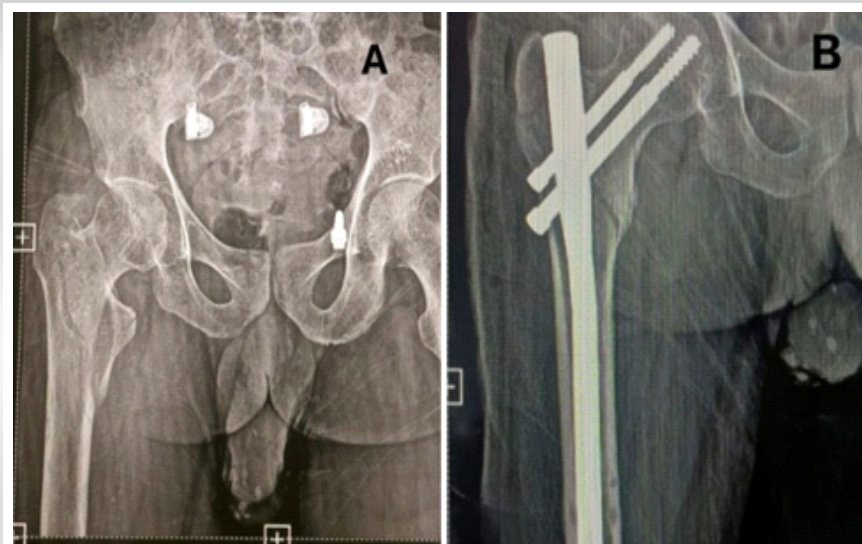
(a) Pre-operative anterior-posterior (A-P) view X-ray showing TYPE 31-A2.1 pertrochanteric femur fracture of the right side. (b) Post-operative A-P view X-ray showing pertrochanteric femur fracture fixed with long proximal femur nail.
